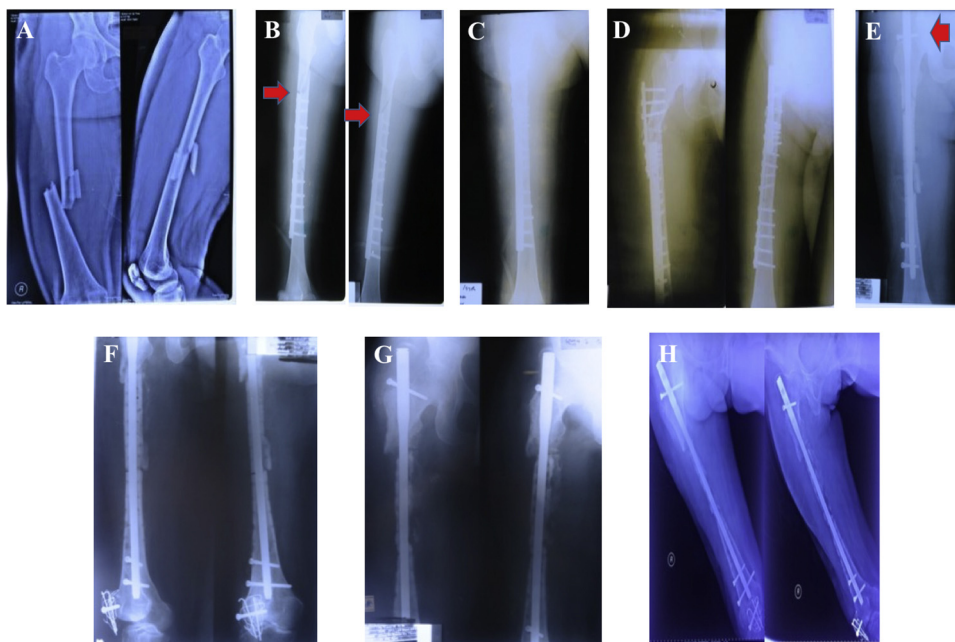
AP and Lateral Femur X-rays before presenting to our hospital; A: Initial presentation; B: Post Operative-1 showing missing plate and screw in fixing the proximal fracture above the plating; C: Two weeks Post Operative-2 showing another proximal plating; D: Post Operative-3 showing proximal plating failure; E: Intramedullary nailing conversion showing improper nail insertion and locking fixation; F: Femur nailing has been revised and patellar fracture was fixed with screw and wire; G: Three months post-operative; H: Five months post-operative showing infected and sequestered middle segment of femoral shaft.
